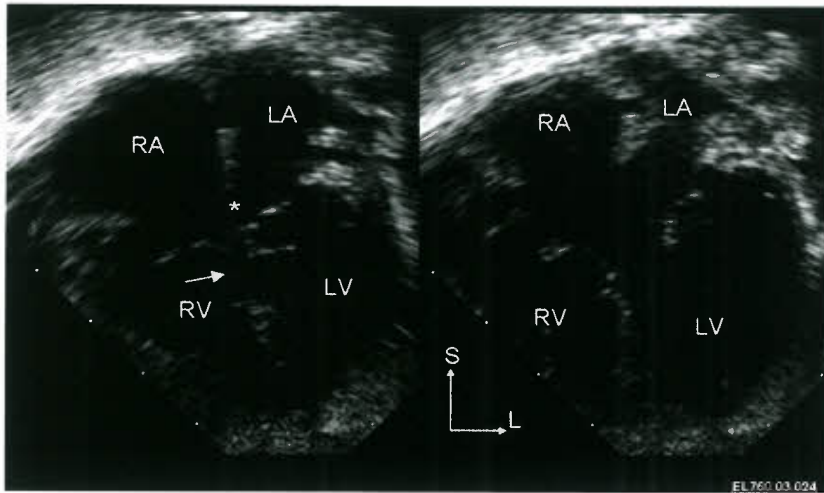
Complete AVSD: Apical four-chamber images in systole (left) and diastole (right) demonstrating a complete AVSD with large primum ASD (*asterisk*), large inlet VSD (*arrow*), and common single-orifice AV valve. The right panel demonstrates the valve opening as a single unit with only lateral “hinge points” visible in this image. Biventricular volume overload and a small secundum ASD are present in this patient.
